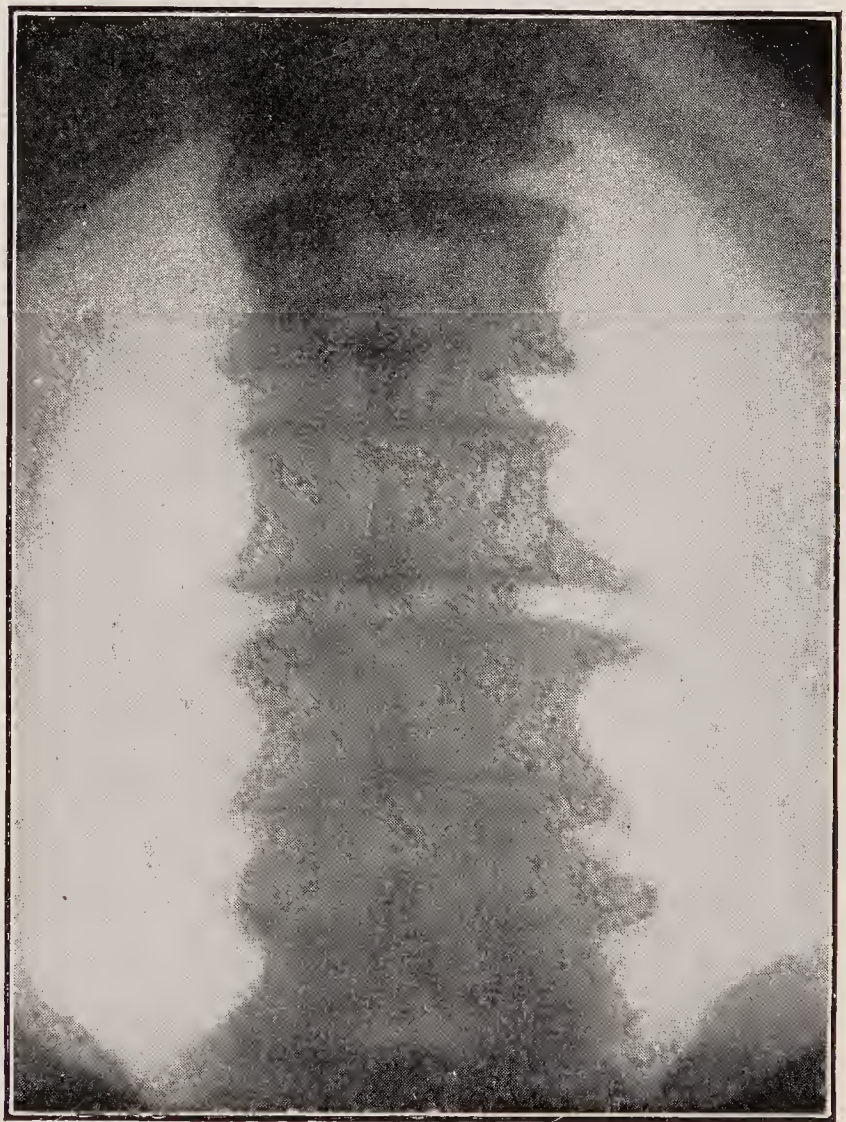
X-ray, showing lipping of vertebræ.
